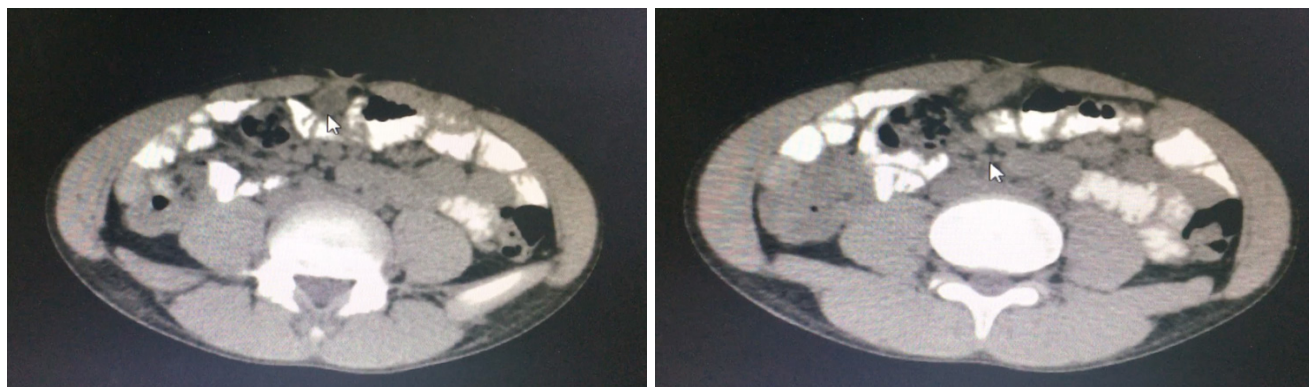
Contrast-enhanced CT showed cystic lesion 1.7 x 1.5 x 1.7 cm underneath umbilical area abutting a small bowel loop without intervening fat plane.
